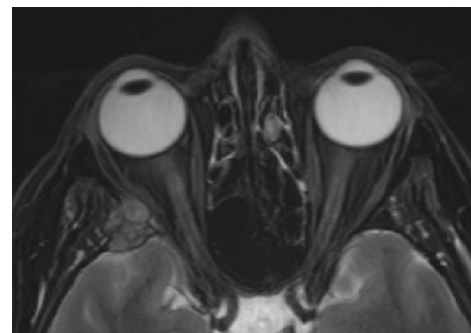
An MRI scan showing a tumor in the anterior middle cranial fossa, extending into the lateral orbit and displacing the lateral rectus muscle. This tumor was removed in a combined surgery with oculoplastic surgeons and neurosurgeons. The surgeons used a transorbital approach with eyelid crease incision.
